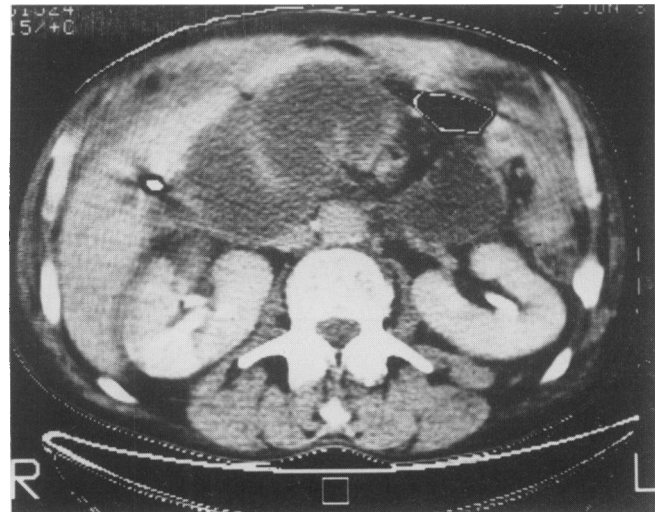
CT 8 days after a Whipple procedure showing dilated, edematous jejunal loop in the immediate subhepatic space.
